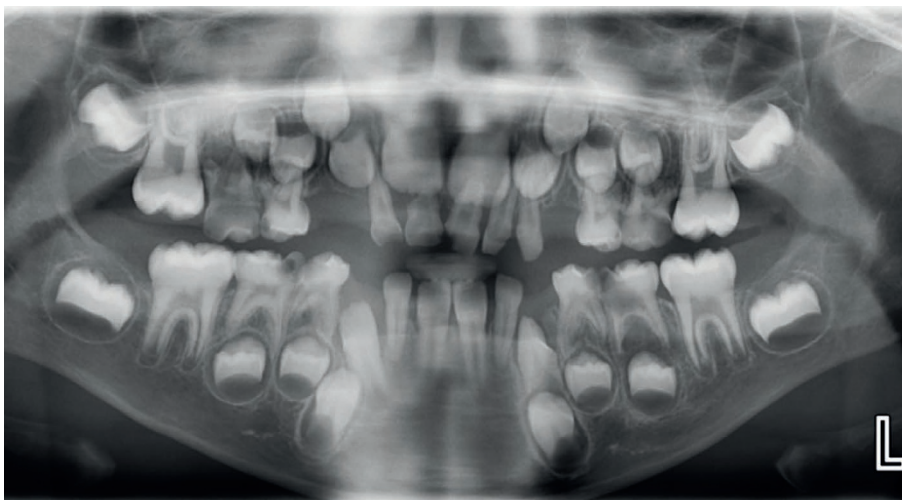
DPT radiograph showing an extensively carious primary dentition, diminutive 63, absence of 53, 73, 83 URC, LLC, LRC and distally positioned 32 and 42
